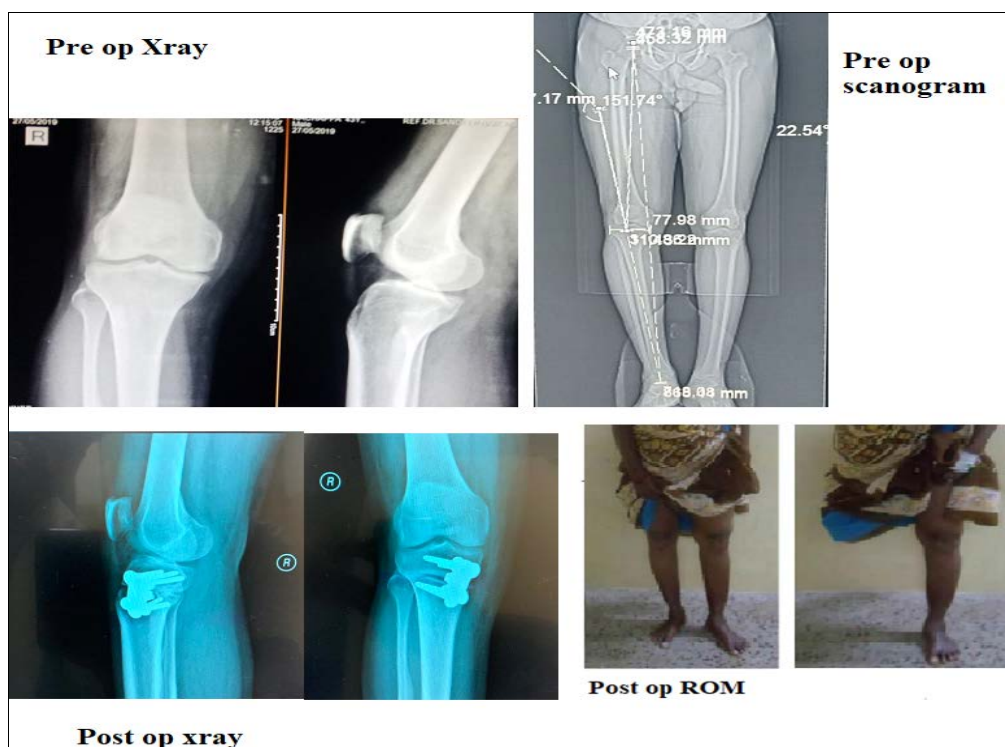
Case 2 -radiographs and clinical pictures
